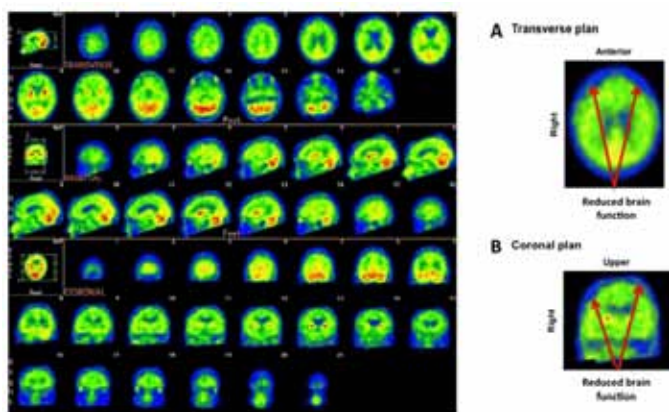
¹⁸F-FDG PET scan of the brain of a female patient affected by osmotic demyelination syndrome obtained ninety days after hospitalization. It shows an overall reduction in ¹⁸F-FDG uptake in the bilateral frontotemporal cortex because of a reduced brain function due to a diffuse brain damage. The residual brain function was established in absence of medical treatment and metabolic disorders.
